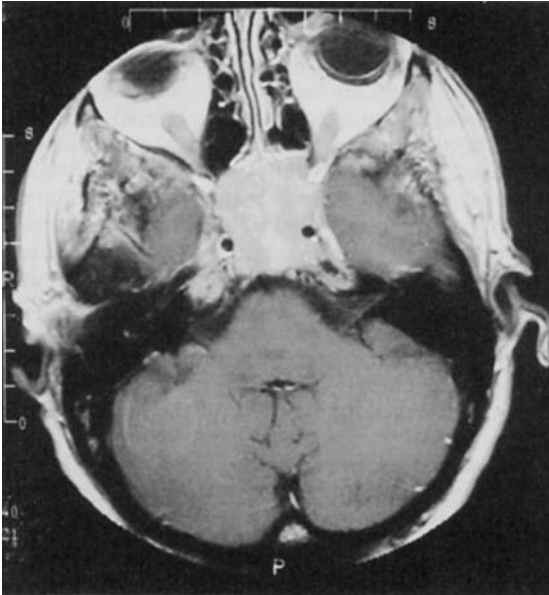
Plasmacytoma. A large enhanced mass on this postgadolinium T1-weighted MR image expands the clivus and represents a plasmacytoma. Many of these patients will eventually develop multiple myeloma.
